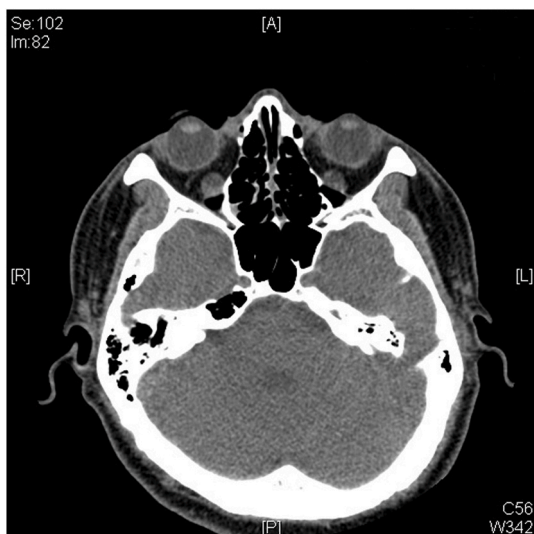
Computed tomography scan of bilateral orbits.
